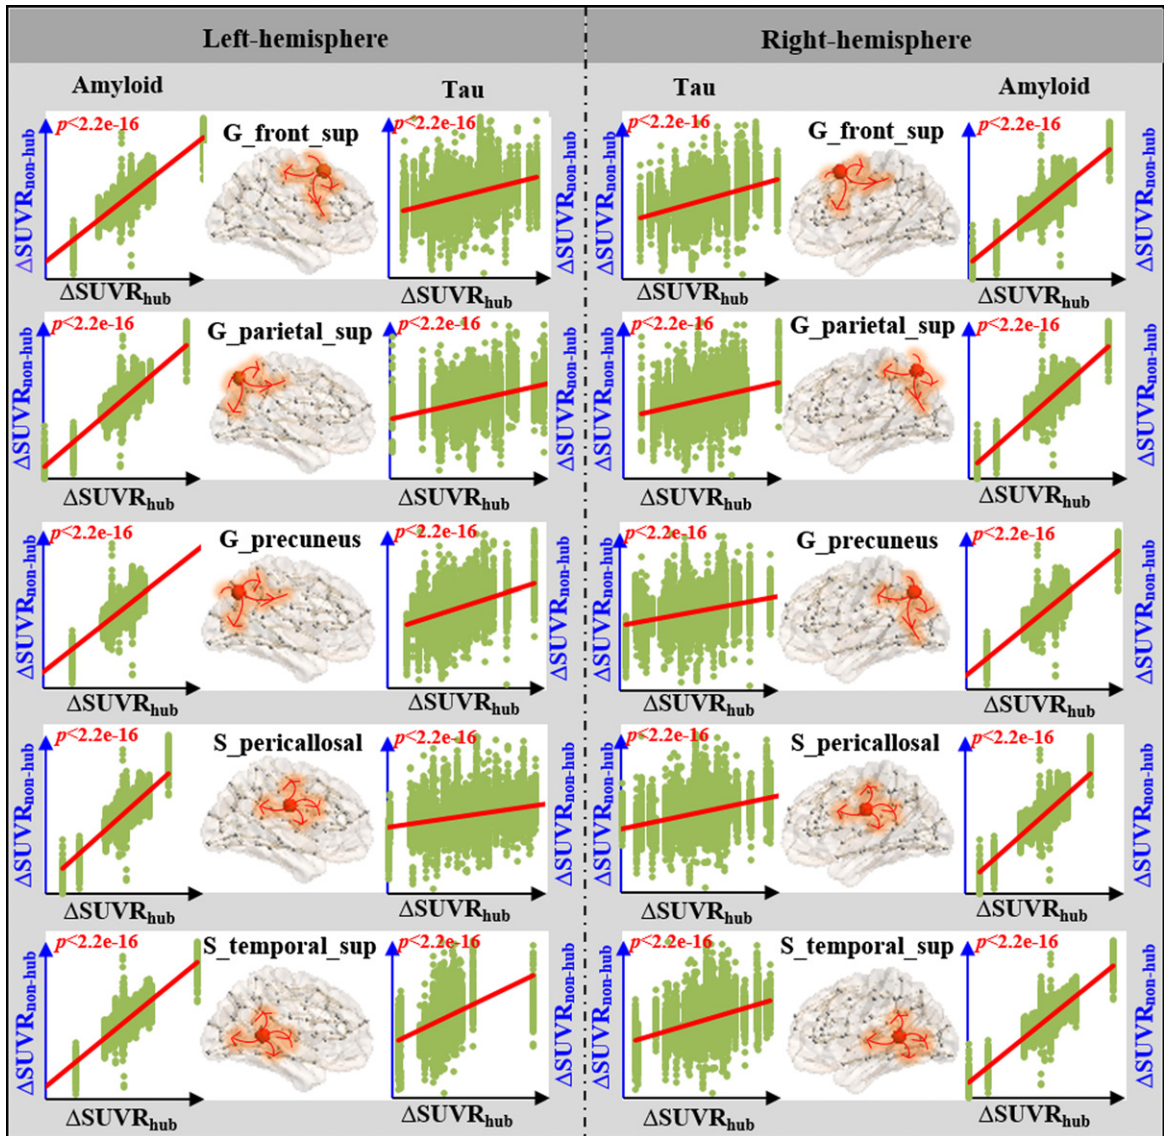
SUVR level changes of pathological proteins (amyloid- β or tau) at non-hub nodes ($\Delta\text{SUVR}_{\text{non-hub}}$) versus SUVR level changes of pathological proteins at the hub node ($\Delta\text{SUVR}_{\text{hub}}$). The left half of the figure shows the relative results of the five hub nodes in the left hemisphere, and the right half of the figure shows the relative results of the corresponding five hub nodes in the right hemisphere.
